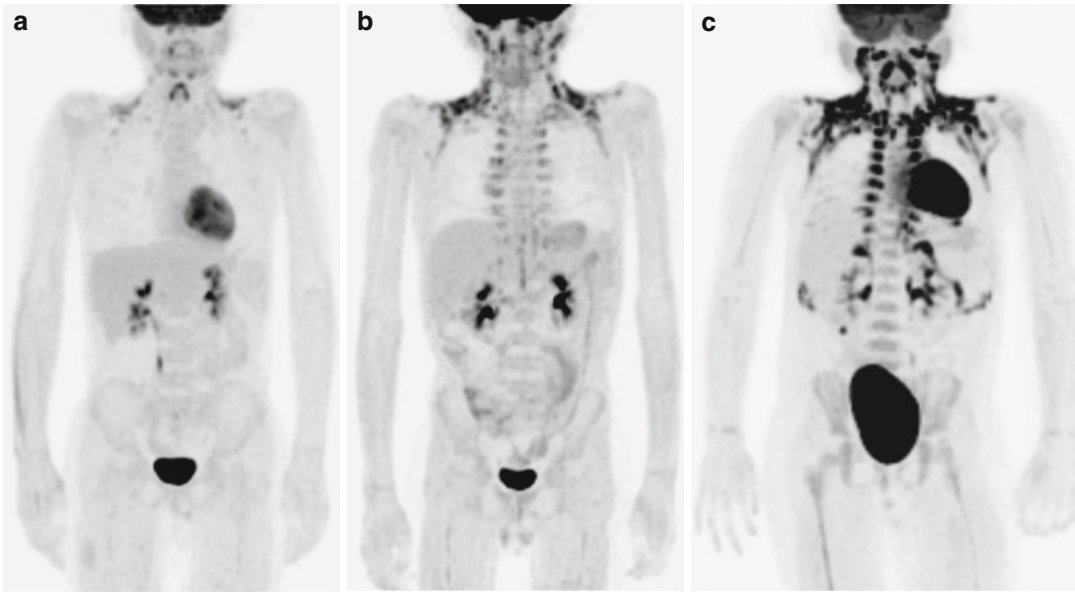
Fluorine-18-FDG uptake in brown adipose tissue. Increased ^{18}F -FDG uptake in brown adipose tissue can be a common finding on ^{18}F -FDG PET of the body. Many pediatric patients may demonstrate a mild degree of brown adipose uptake (a), but some may have moderate (b) or marked (c) uptake. Extensive uptake in brown
